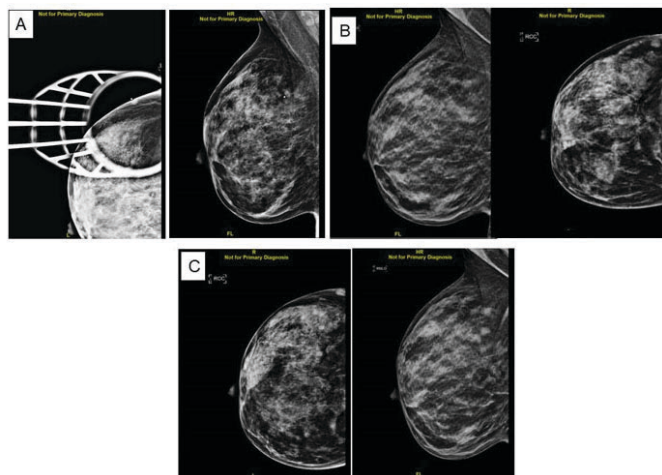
Bilateral diagnostic mammogram and ultrasound. (A) Obtained in 2017, (B) Obtained in 2021, (C) Obtained in 2023.
